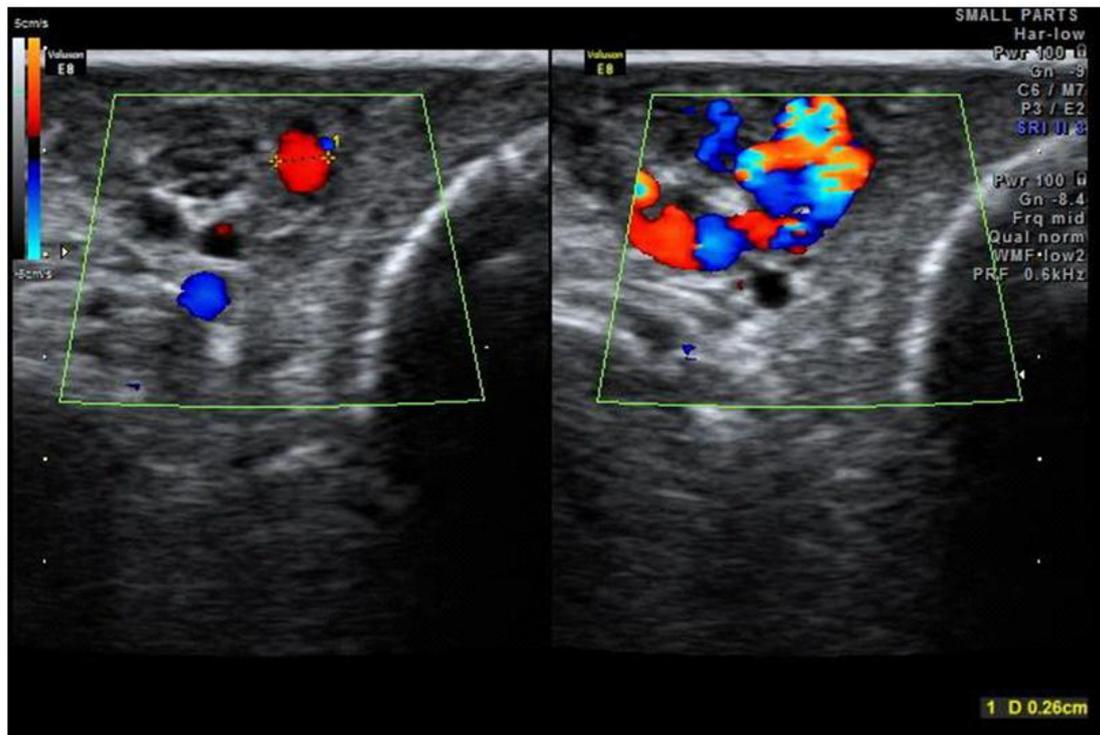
Left scrotum : prominent anechoic vascular channels of left pampinifom plexus. On color Doppler : color flow + & On Valsalva maneuver : reflux +.
